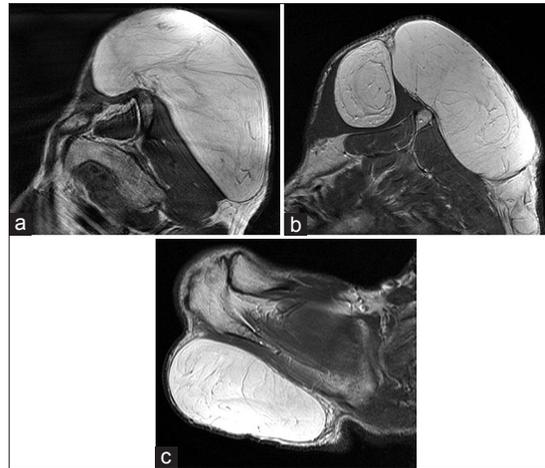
(a, b, c) In contrast-enhanced magnetic resonance imaging, T1 and T2 weighted sections were the same with normal adipose tissue, and there were similar kind of suppression with lipomatous tissue in the fat suppressed images.
